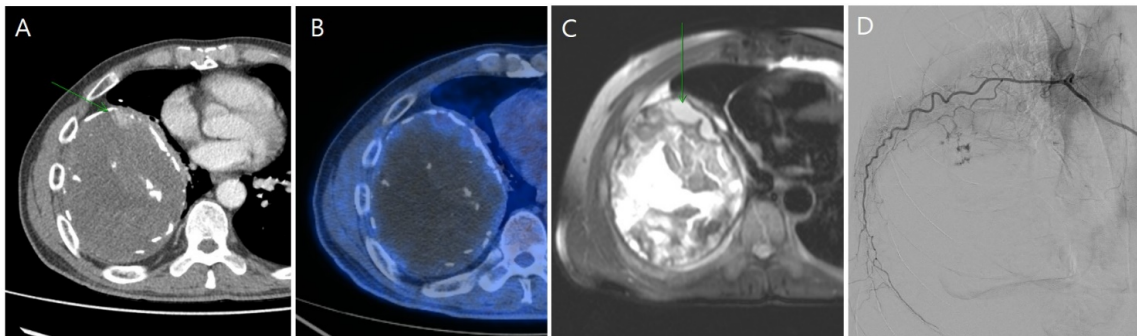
Chest CT scan shows 18mm sized focal enhancing lesion inside the huge mass of right lower thorax.
